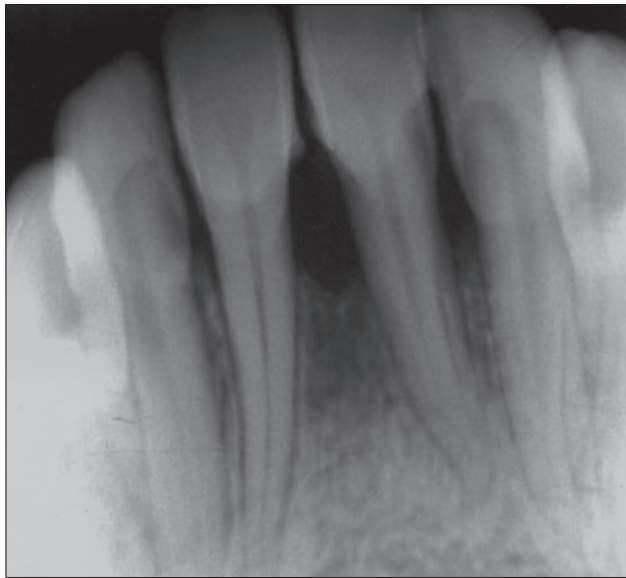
Anterior periapical radiograph of case No. 6. Aggressive periodontitis is evident affecting teeth No. 23, 24, and 25.
